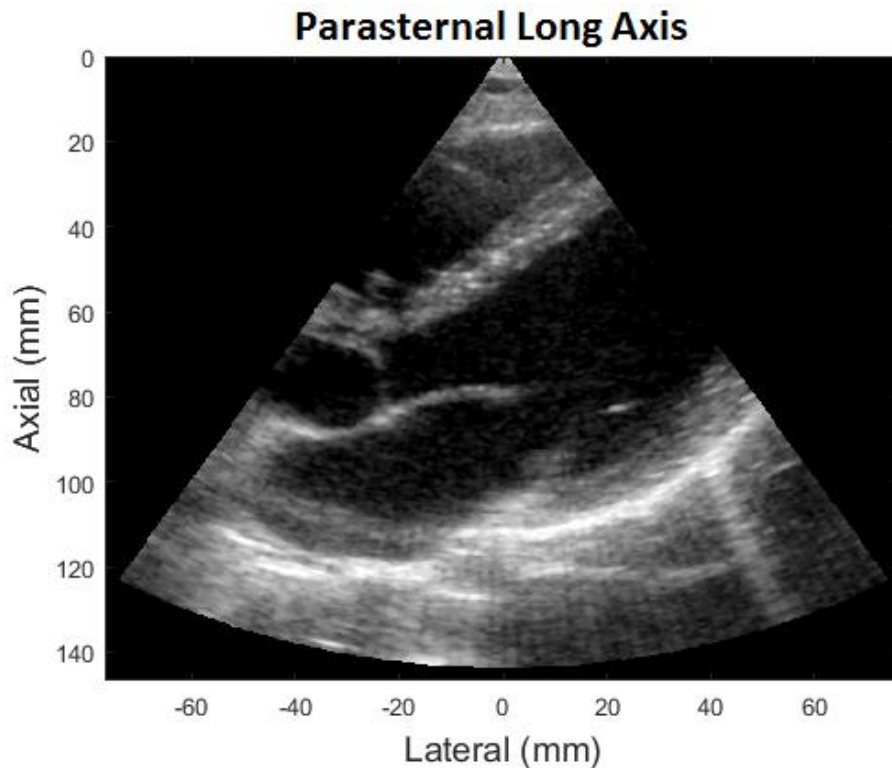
Parasternal long axis view of the heart.
